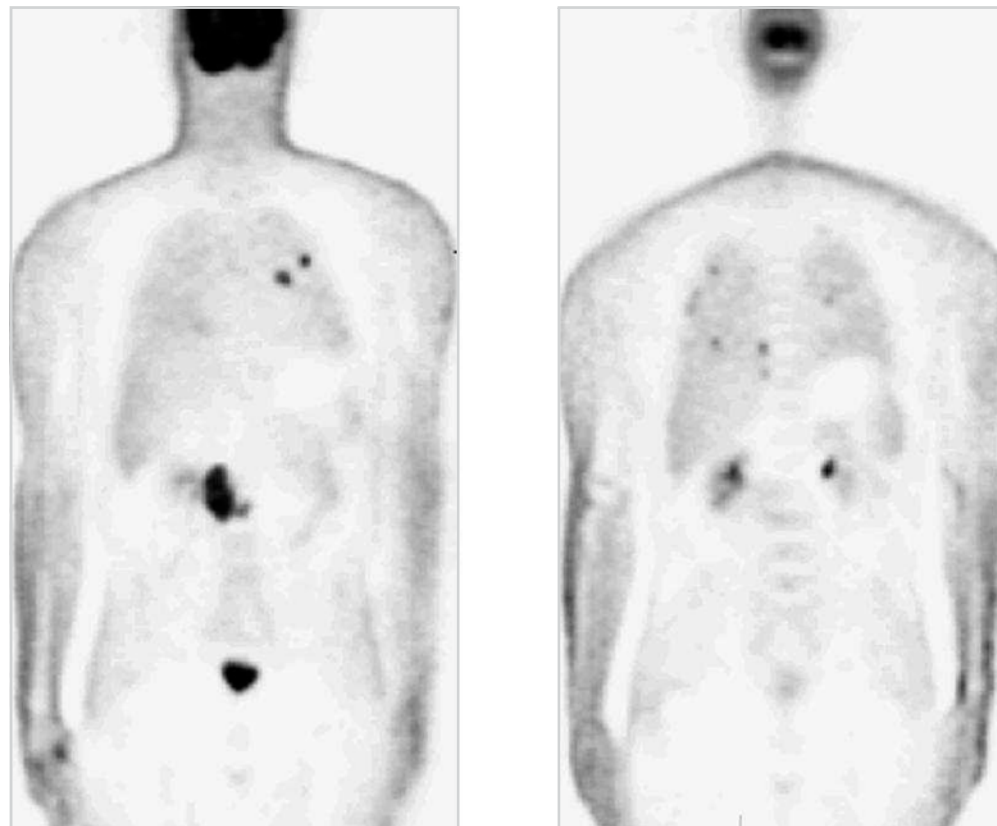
FDG-PET image in a patient with a history of testicular cancer and a right para-aortic residual mass on CT and rising markers. He was being considered for laparotomy as definitive treatment if this was the only site of disease. CT of the abdomen and chest was otherwise normal although he previously had lung metastases. He was referred for a PET scan to exclude other sites of disease and thereby enable surgery. The images show increased uptake in the known mass as well as disease in the lungs and mediastinum, which directly altered the patient's management. 📖
